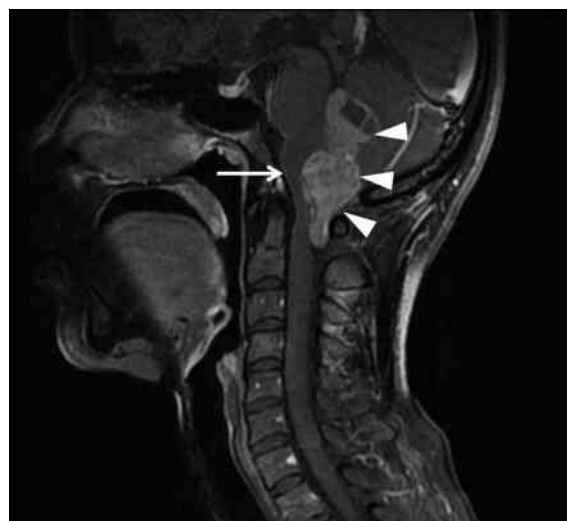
Preoperative contrast-enhanced T1-weighted MRI scans, showing a large ependymoma (white arrowheads) in the fourth ventricle located on the dorsal medulla oblongata (white arrow).
